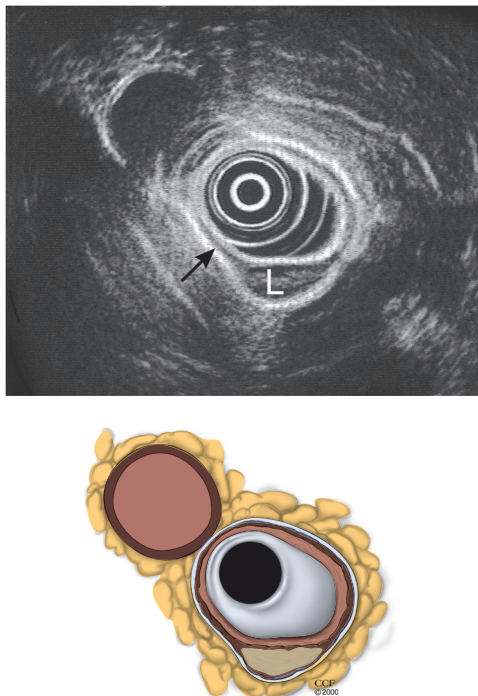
■ An esophageal leiomyoma (L). *Top*: Esophageal ultrasound (EUS) of this most common benign tumor demonstrates a hypoechoic, homogeneous, well-demarcated tumor with no associated lymphadenopathy. EUS balloon overdistention blends the first three ultrasound layers into one hyperechoic layer. Tumor arises from and is confined to the fourth ultrasound layer (arrow). *Bottom*: A benign leiomyoma arises from and is confined to the muscularis propria.
